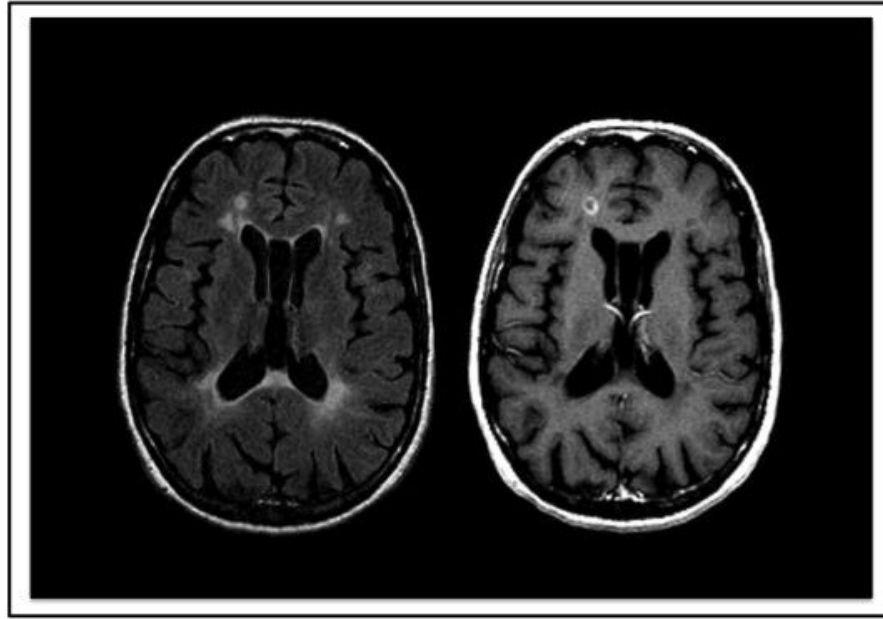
MRI of the brain post-gadolinium injection in one MS patient. Periventricular lesions are seen as hyperintense foci on Flair image (left). Recent area of inflammation enhances after gadolinium injection on T1-weighted scan (right)
